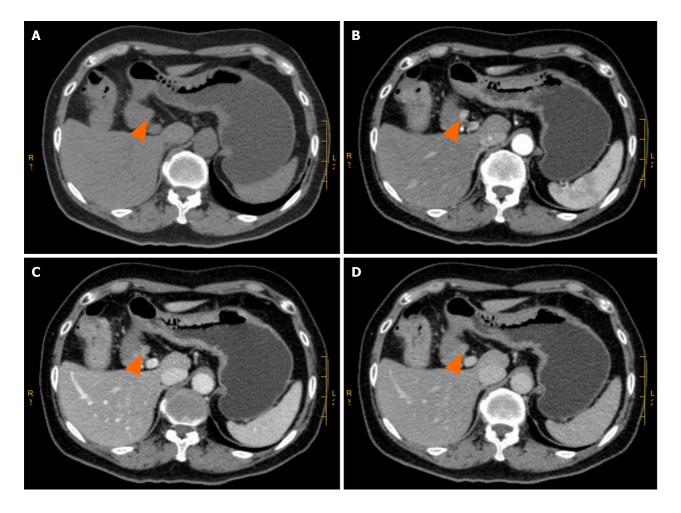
Enhanced total abdominal computed tomography findings. A: Computed tomography (CT) plain scan of a mass in the duodenal bulb; B: Abnormal enhancement of the duodenal bulb (orange triangles); C and D: CT venous phase and CT venous delayed phase of the mass, respectively.
